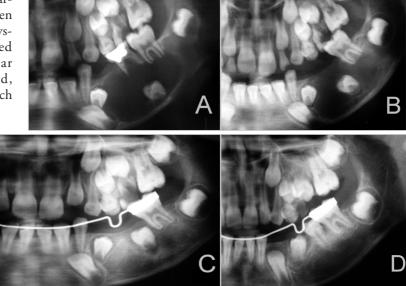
Panaromic radiographs. (A) Radiograph view demonstrating the dentigerous cyst related to the unerupted second premolar. (B) Postoperative radiographic view after 3 months displaying the decreased radiolucency around the second premolar. (C) Postoperative view after 6 months showing the displacement of the second premolar toward the occlusal ridge. (D) Radiographic view showing the eruption of the second premolar after 21 months.
